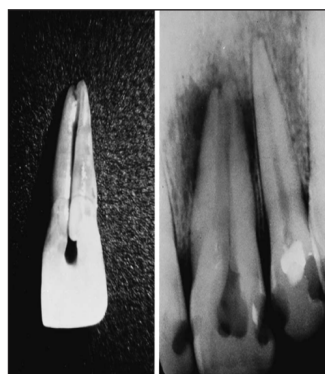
Radiograph showing broken instrument crossing apex
